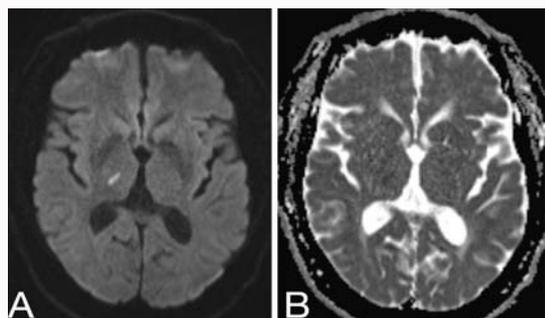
MRI showing area of diffusion restriction on diffusion weighted imaging (A) in the region of the right ventral posterior nucleus of the thalamus with correlate on the apparent diffusion coefficient (B) imaging consistent with acute infarct.
